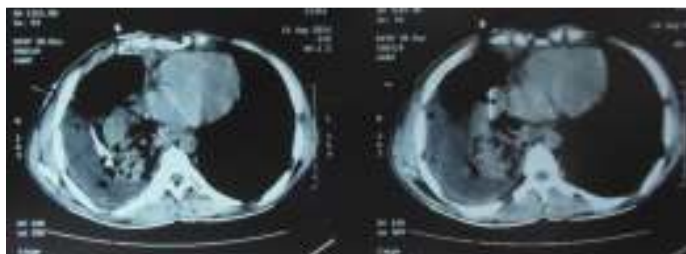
CT scan thorax with CT guided FNAC from right lung consolidation
